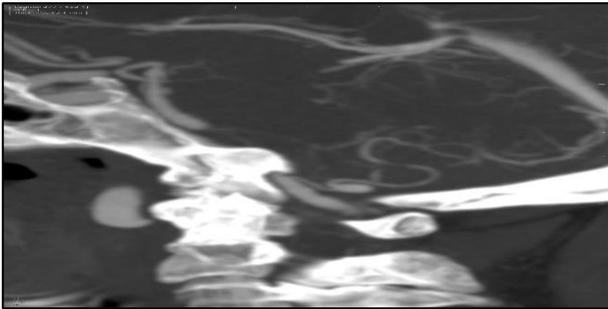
Sagittal contrast CT angiography MIP image showing distal pica aneurysm.
